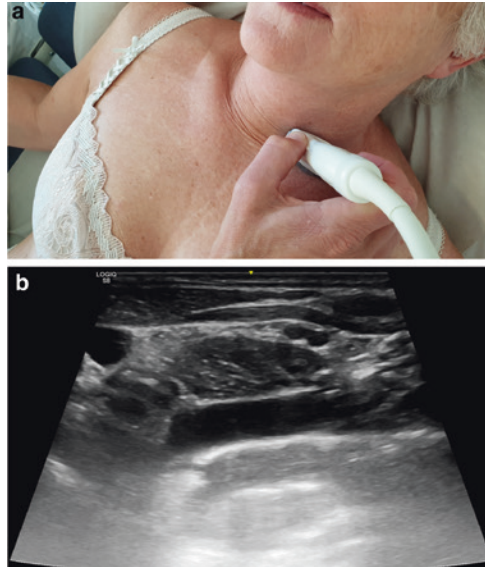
Examination of the left subclavian artery: a recommended transducer position, b ultrasonographic view of the left subclavian artery
